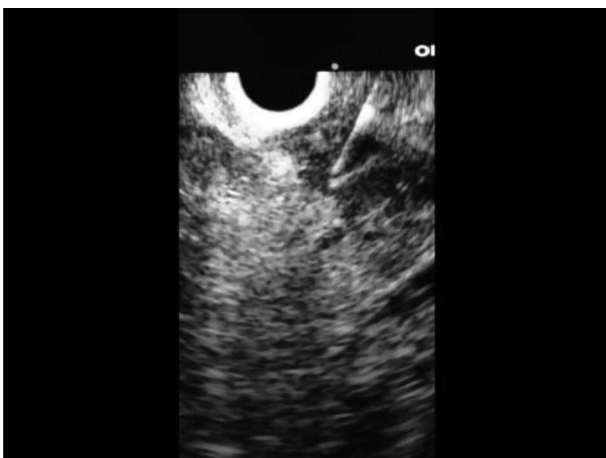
Linear EUS view of a 5 × 5-mm hypoechoic mass lesion arising from the dorsal pancreatic duct in a patient with pancreas divisum. A fine needle aspiration was performed that proved to be positive for adenocarcinoma confirmed at surgery. Computed tomography in this patient showed a dilated pancreatic duct with no obvious mass lesion.
